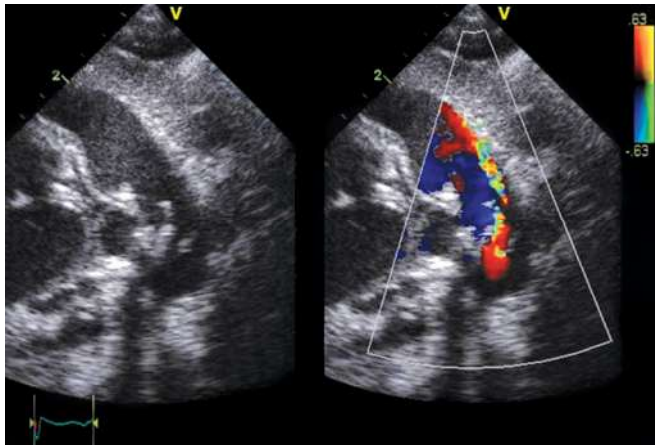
Patent ductus arteriosus—colour Doppler echocardiogram
